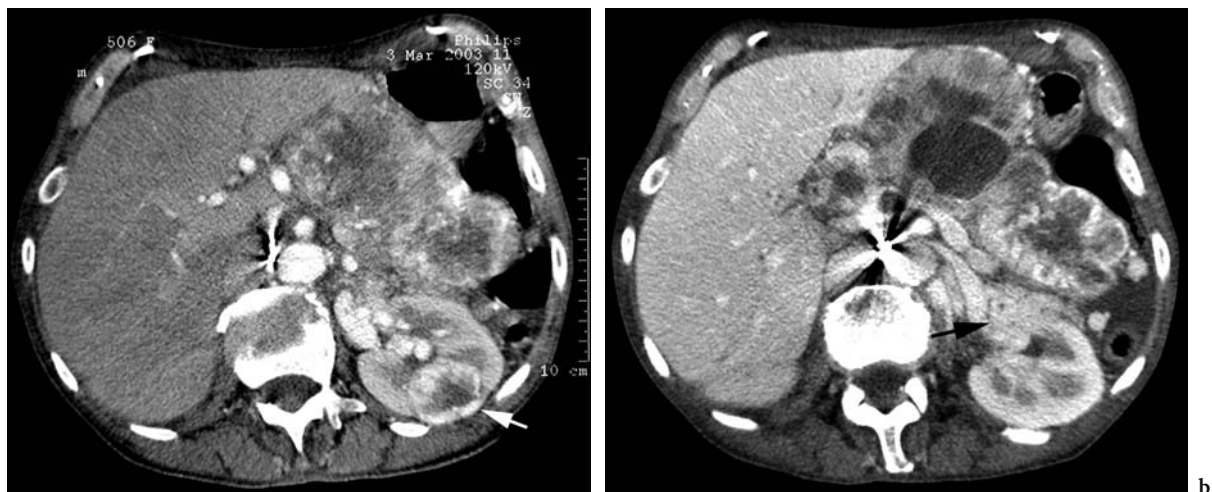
Peritoneal carcinomatosis and contralateral kidney metastases in a 80-year-old woman who underwent right nephrectomy for renal cell carcinoma. a, b Axial contrast-enhanced CT scans show extensive widespread heterogeneous peritoneal infiltration with solid and cystic components associated with ascites. There are also heterogeneous enhancing masses of the left kidney of a posterior (*arrow*) and b anterior (*arrow*) locations.
